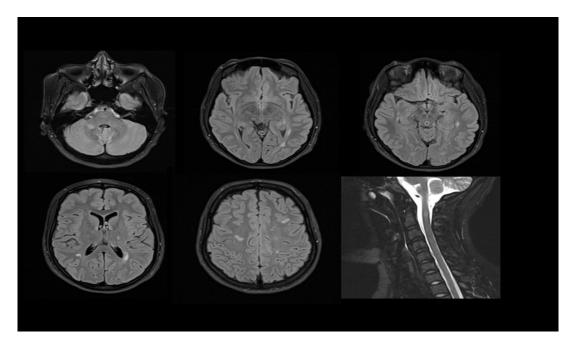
Axial T2-Flair MRI showed multiple brain lesions and cervical spine lesions.
